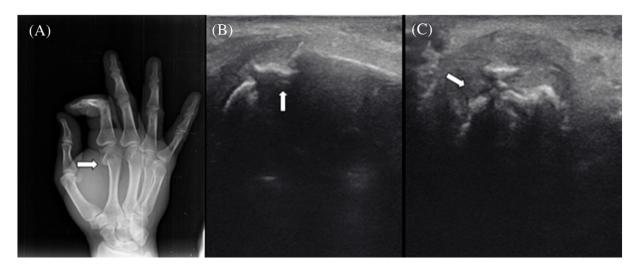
Oblique x-ray (A) and longitudinal (B) and transverse (C) and USG views of the first metacarpal fracture.
